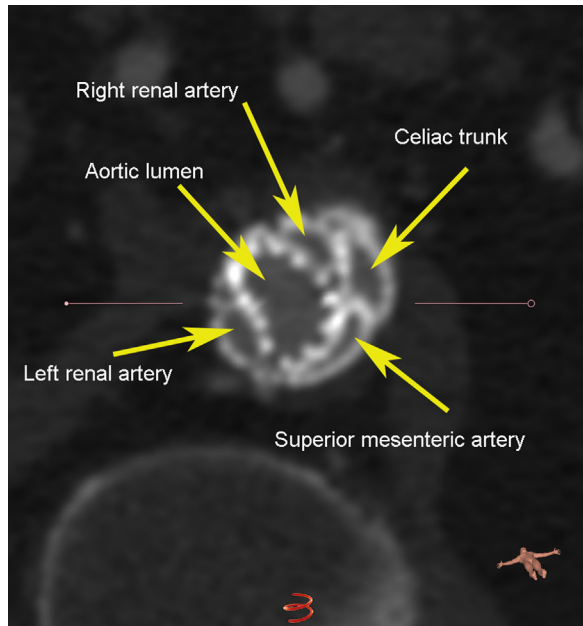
Computed tomography (CT) angiography transverse reconstruction after 4-month follow-up. The arrows indicate the chimney grafts in position in the superior mesenteric artery (SMA), celiac trunk, left renal artery, right renal artery, and the aortic lumen.
